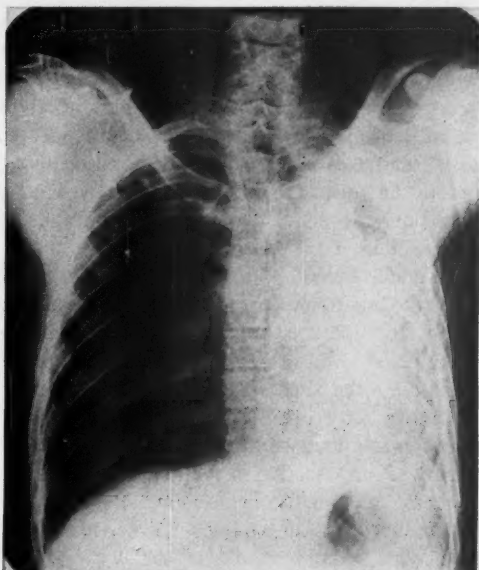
Postoperative roentgenogram of patient with destroyed left lung
